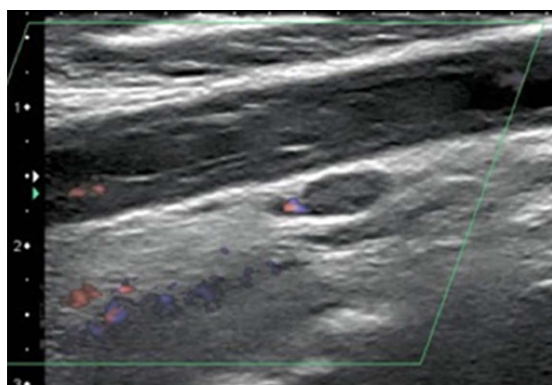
Color duplex sonography findings. There is a floating thrombus of the distal common carotid artery.
